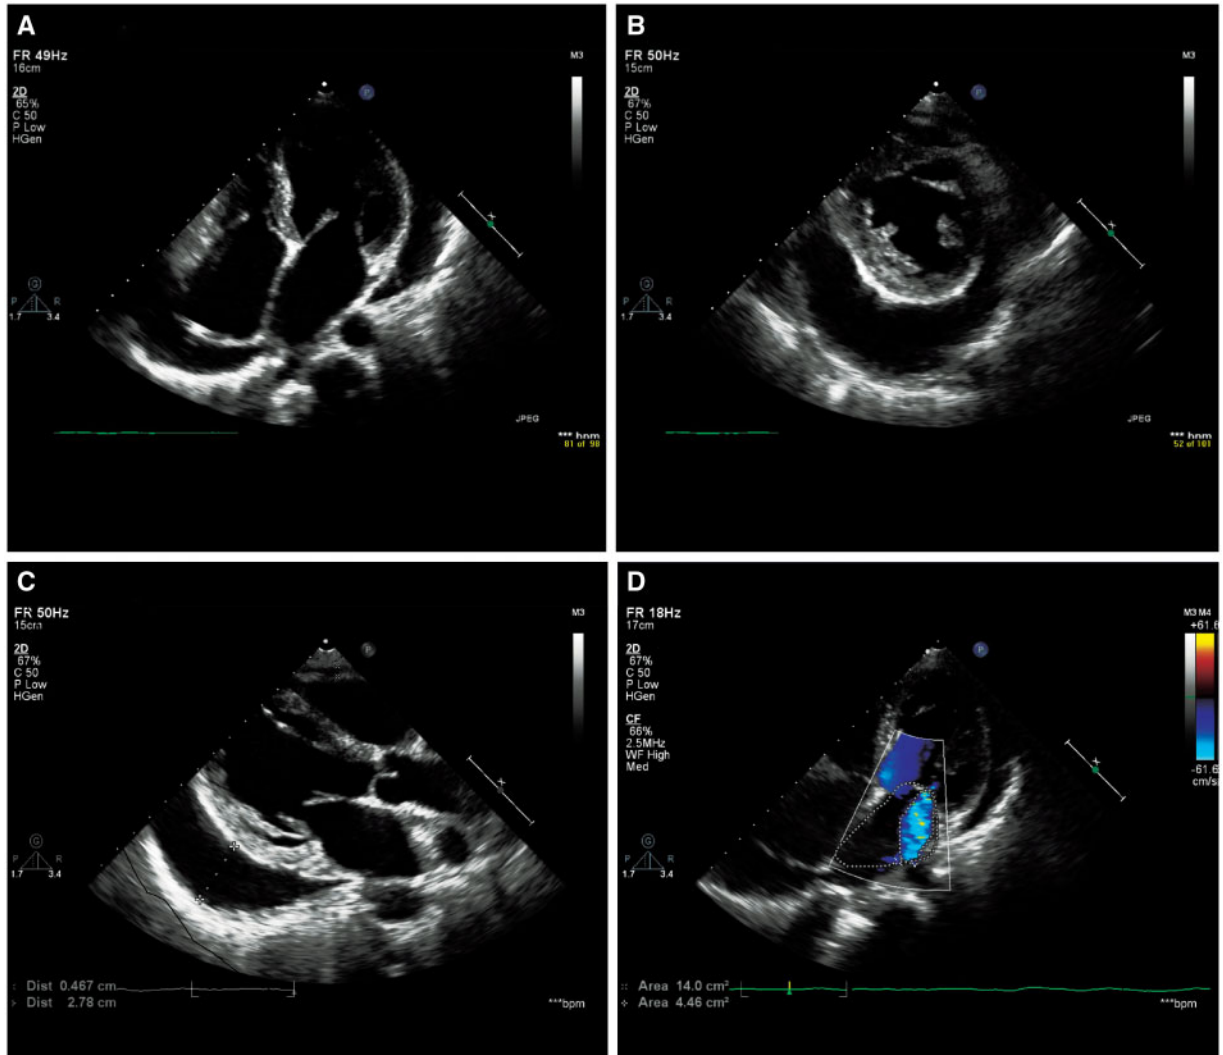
Echocardiogram showing left ventricular hypertrophy and pericardial effusion. (A) Apical four-chamber view. (B) Short-axis view. (C) Parasternal long-axis view. (D) Mitral regurgitation.
